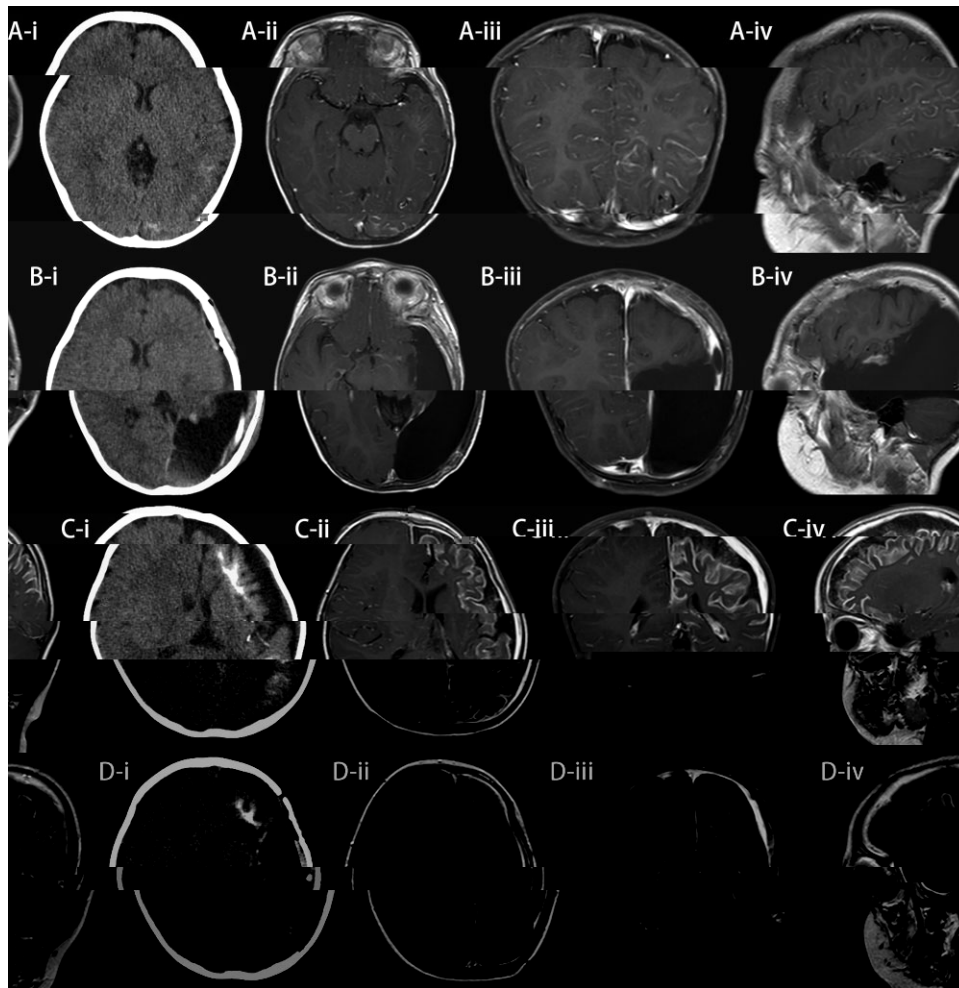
Pre- and postoperative CT and MRI of two patients with SWS who underwent multilobe resection. (A and B: left temporal-parietal-occipital resection) and hemisphere surgery (C and D: left MH). [A(i)] Preoperative CT (axial image); [A(ii)] preoperative MRI (enhanced T₁-weighted image, axial image); [A(iii)] preoperative MRI (enhanced T₁-weighted image, coronal image); [A(iv)] preoperative MRI (enhanced T₁-weighted image, sagittal image); [B(i)] postoperative CT (axial image); [B(ii)] postoperative MRI (enhanced T₁-weighted image, axial image); [B(iii)] preoperative MRI (enhanced T₁-weighted image, coronal image); [B(iv)] postoperative MRI (enhanced T₁-weighted image, sagittal image); [C(i)] preoperative CT (axial image); [C(ii)] preoperative MRI (enhanced T₁-weighted image, axial image); [C(iii)] preoperative MRI (enhanced T₁-weighted image, coronal image); [C(iv)]: preoperative MRI (enhanced T₁-weighted image, sagittal image); [D(i)] postoperative CT (axial image); [D(ii)] postoperative MRI (enhanced T₁-weighted image, axial image); [D(iii)] postoperative MRI (enhanced T₁-weighted image, coronal image); [D(iv)] postoperative MRI (enhanced T₁-weighted image, sagittal image).
